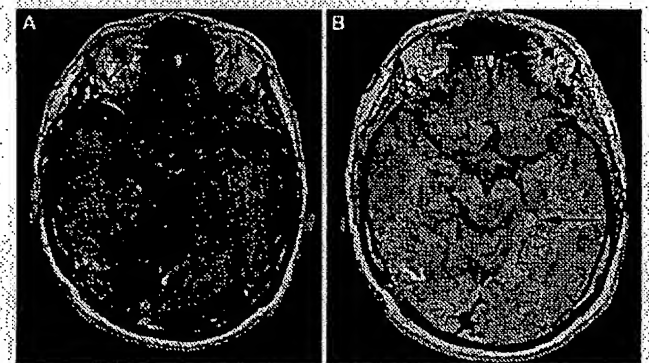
MRI scans for a patient with a glioblastoma after an excellent response to temozolomide, a new oral chemotherapeutic drug that crosses the BBB very well. Residual disease was assessed on T1-weighted MRI scans, with two intravenously administered contrast agents. A, gadolinium-enhanced scan. B, ferumoxtran-10-enhanced scan. The residual lesion in the right hemisphere, which can be clearly observed with both gadolinium and ferumoxtran-10, should be noted. A left-side lesion that is not well detected with gadolinium but is easily observed with iron (arrows) should also be noted.
